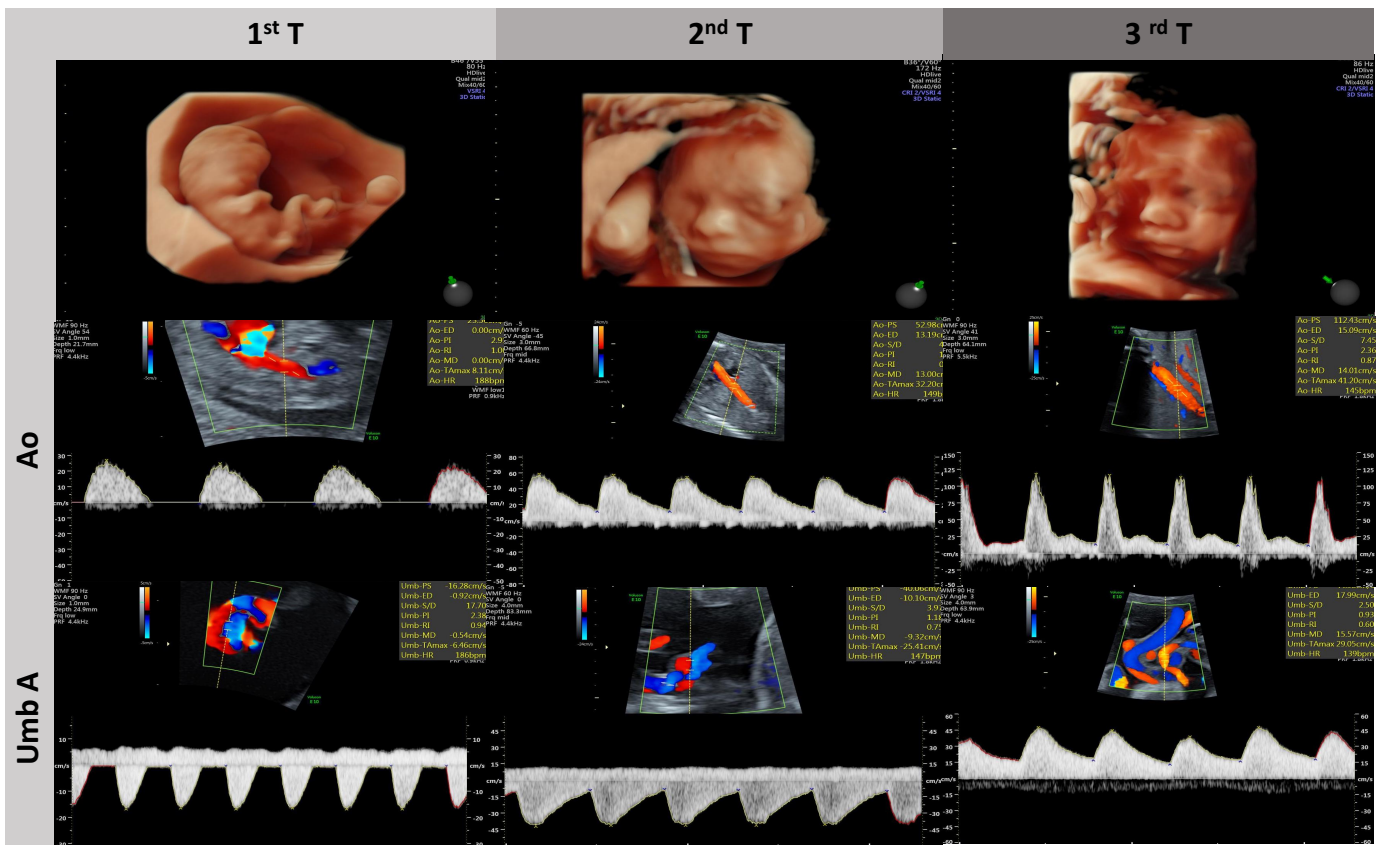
Doppler ultrasound of the aortic (Ao) and the umbilical arteries (UmbA) during the first trimester (1stT), second trimester (2ndT) and third trimester (3rdT)
